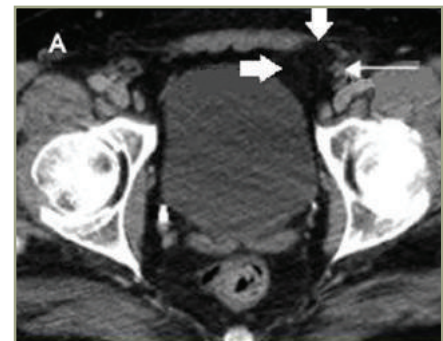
CT of direct inguinal hernia (larger arrows) located medial to the inferior epigastric vessels (smaller arrow).
